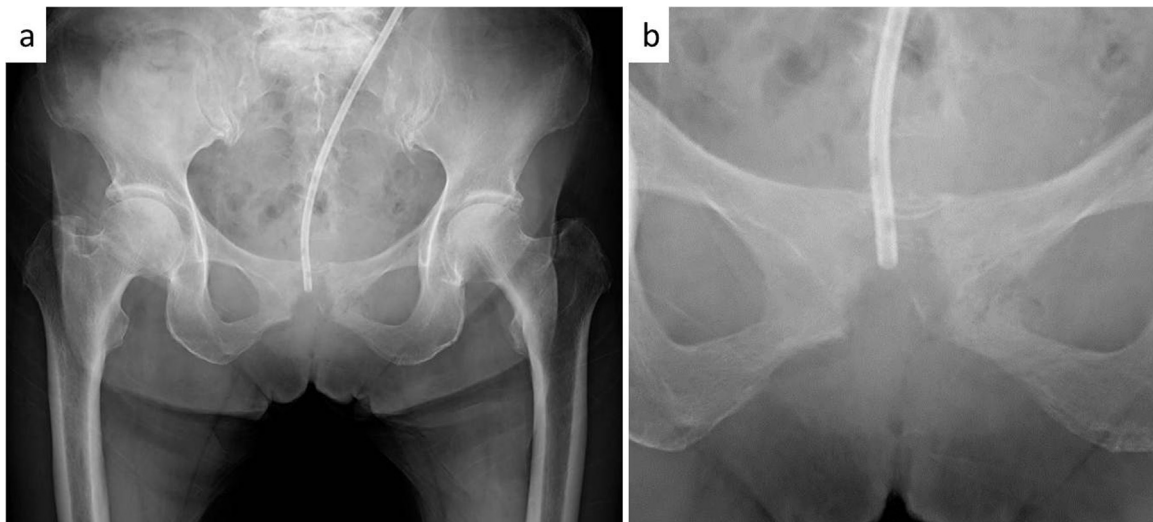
a. Plain radiograph of the pelvis demonstrated severe atrophy and irregularity of the cortex of the pubic symphysis. b. Close-up image of pubic symphysis.
